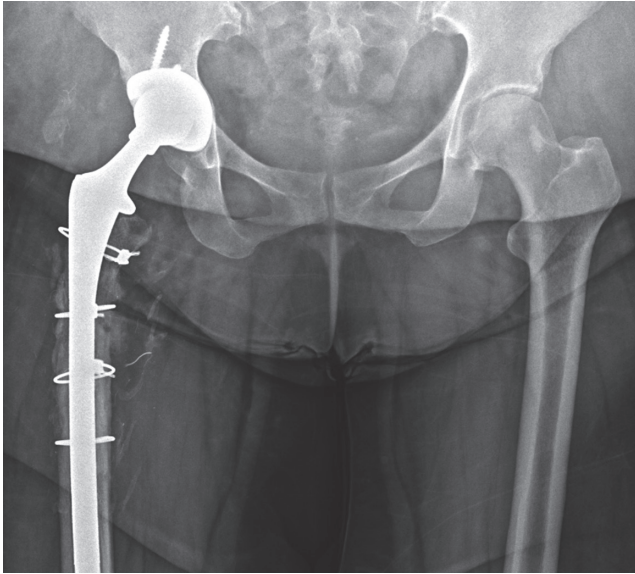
Postoperative x-ray image: revision of the femoral stem and fixation of the trochanteric osteotomy.
